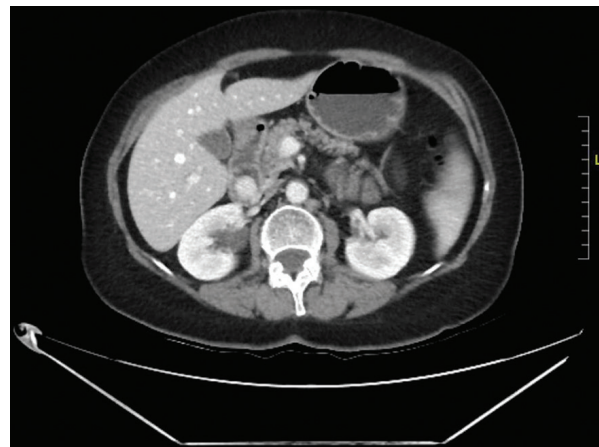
Computed tomography image showing duodenal gastrointestinal stromal tumor in 2nd portion.
